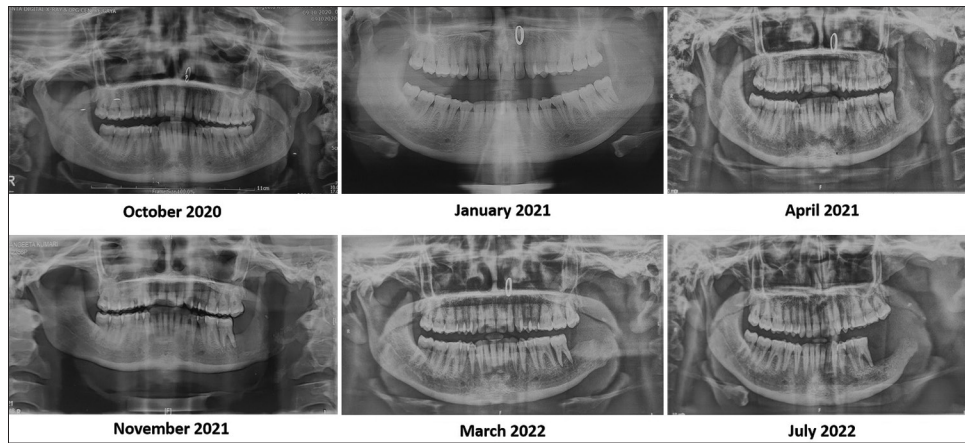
Radiographic and imaging analysis. Serial OPGs revealing slowly progressive osteolysis of the mandible. OPG: Orthopantomogram
